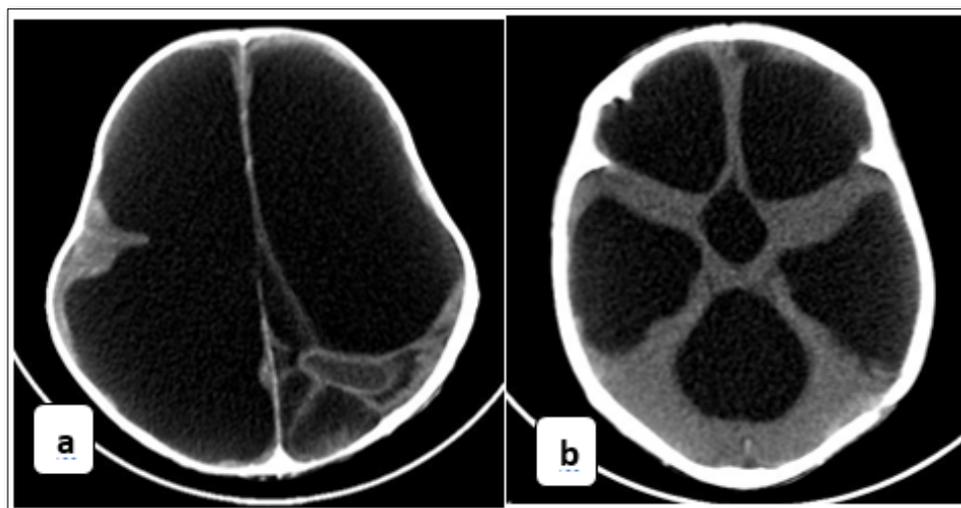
CT scan of ventricular dilation observed in children considered to have advanced hydrocephalus. a) To be noticed is the importance of ventricular dilation and the near disappearance of cerebral parenchyma b) Significant dilation of the 4th ventricle and temporal horns of the lateral ventricles.
